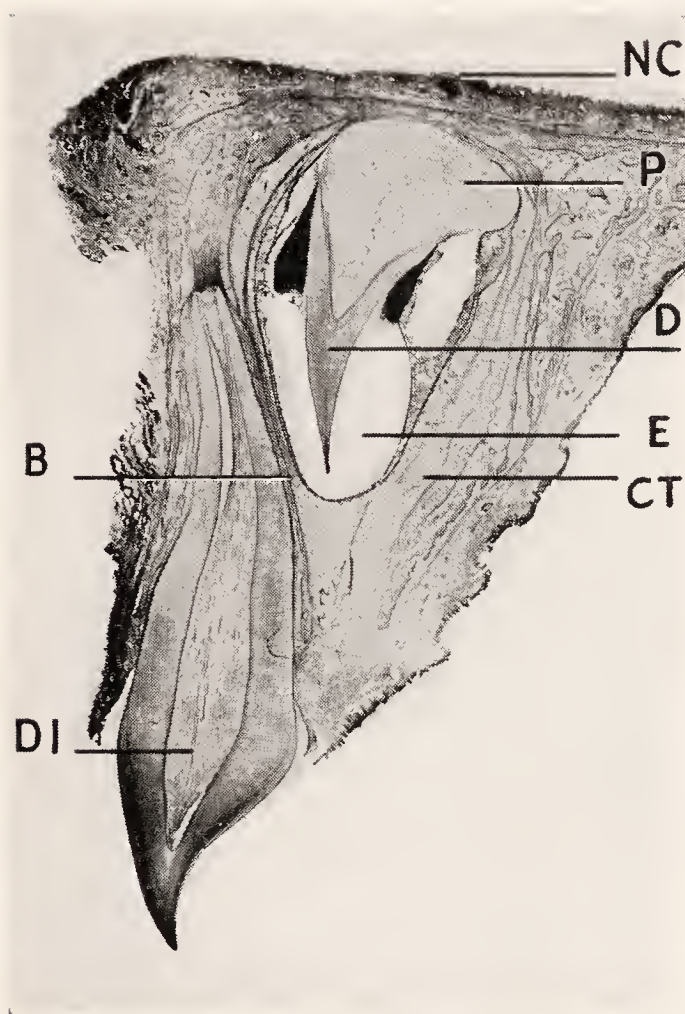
Deciduous and permanent upper central incisor. Labio-lingual section. Age, eighteen months. DI, deciduous incisor; P, pulp of permanent incisor; D, dentin of permanent incisor; E, enamel of permanent incisor; CT, connective tissue capsule surrounding the permanent germ; B, thin plate of bone separating deciduous and permanent tooth; NC, floor of nasal cavity.
